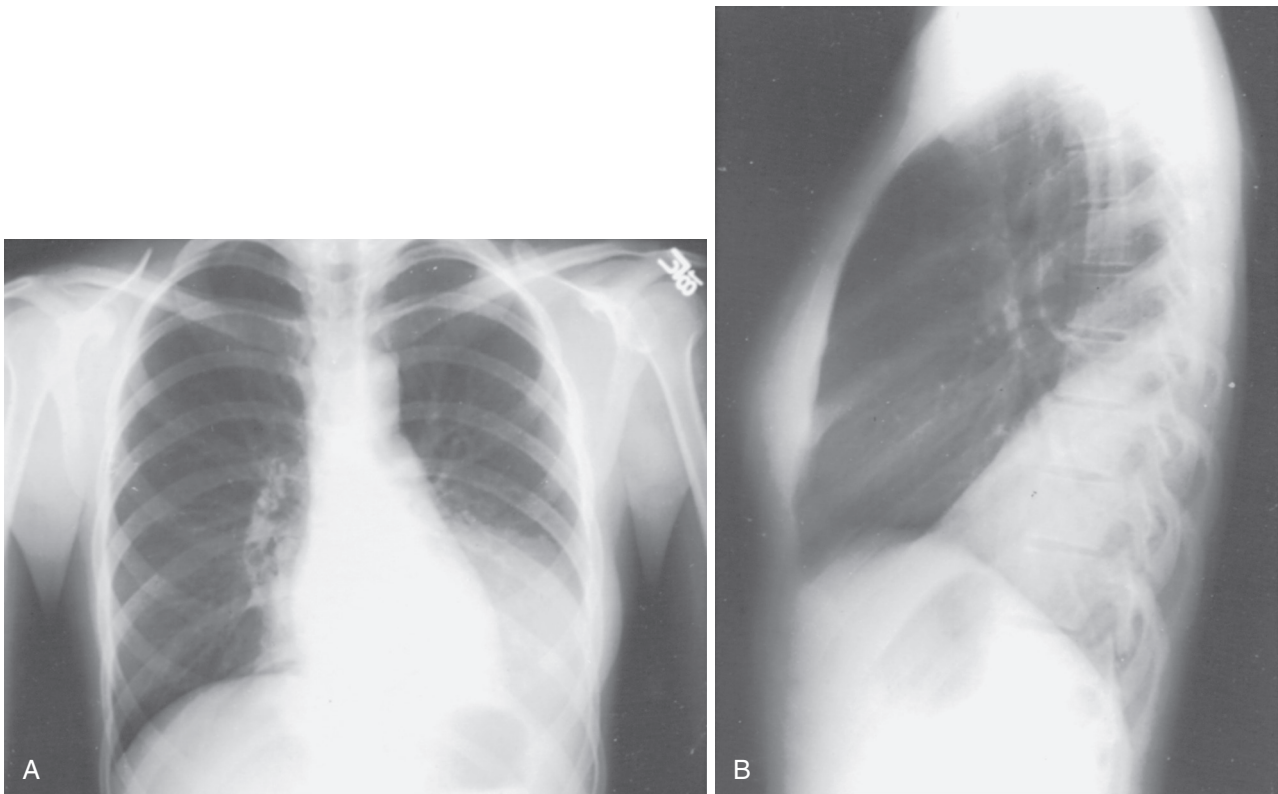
A, Chest radiograph showing dense left lower consolidation consistent with bacterial pneumonia, in this case caused by *Streptococcus pneumoniae*. B, Lateral radiograph of a patient with left lower lobe pneumococcal pneumonia.
